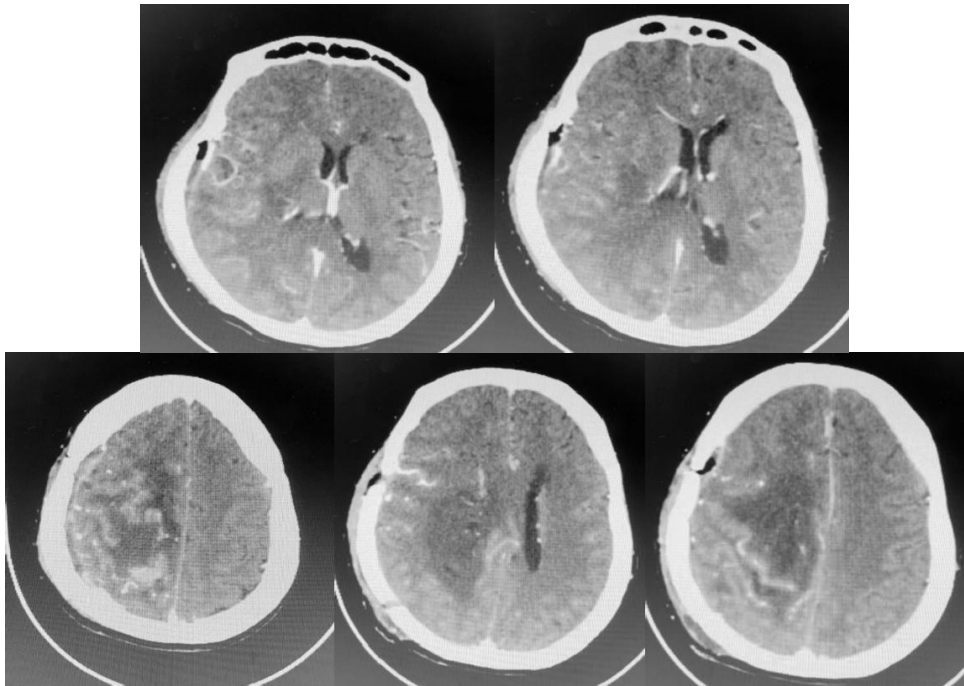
Head CT-Scan with contrast post-craniotomy.
